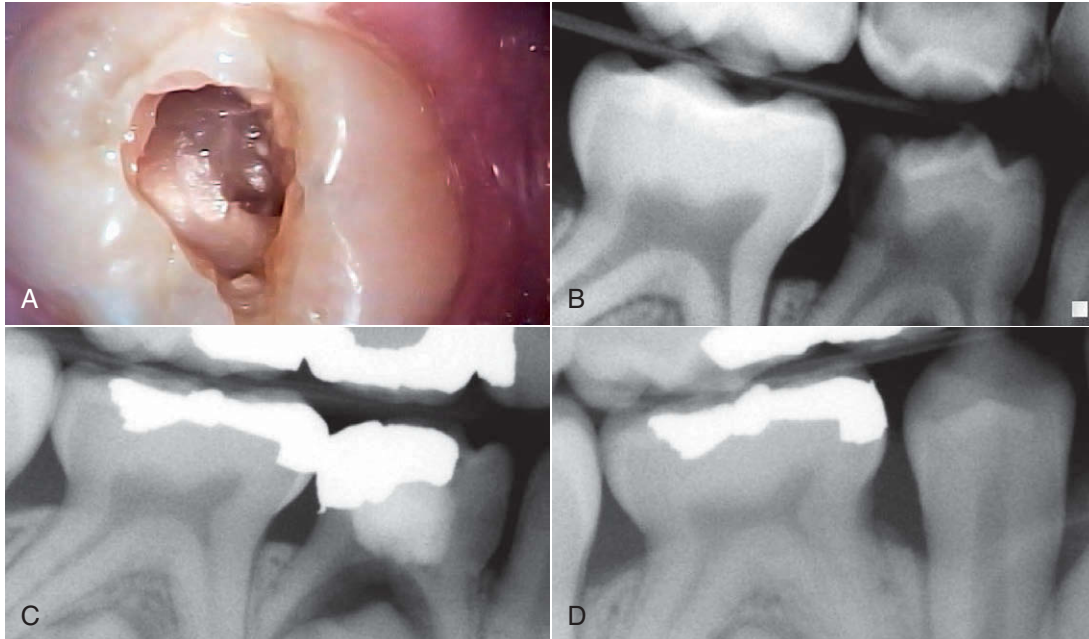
• A, Access for pulpotomy. B, Radiograph of lower first primary molar requiring pulpotomy. C, Radiographic view of completed pulpotomy. This successful laser-assisted treatment allowed the permanent bicuspid to erupt successfully 5 years later. D, Radiograph of 5-year postoperative view showing the permanent bicuspid in place.
